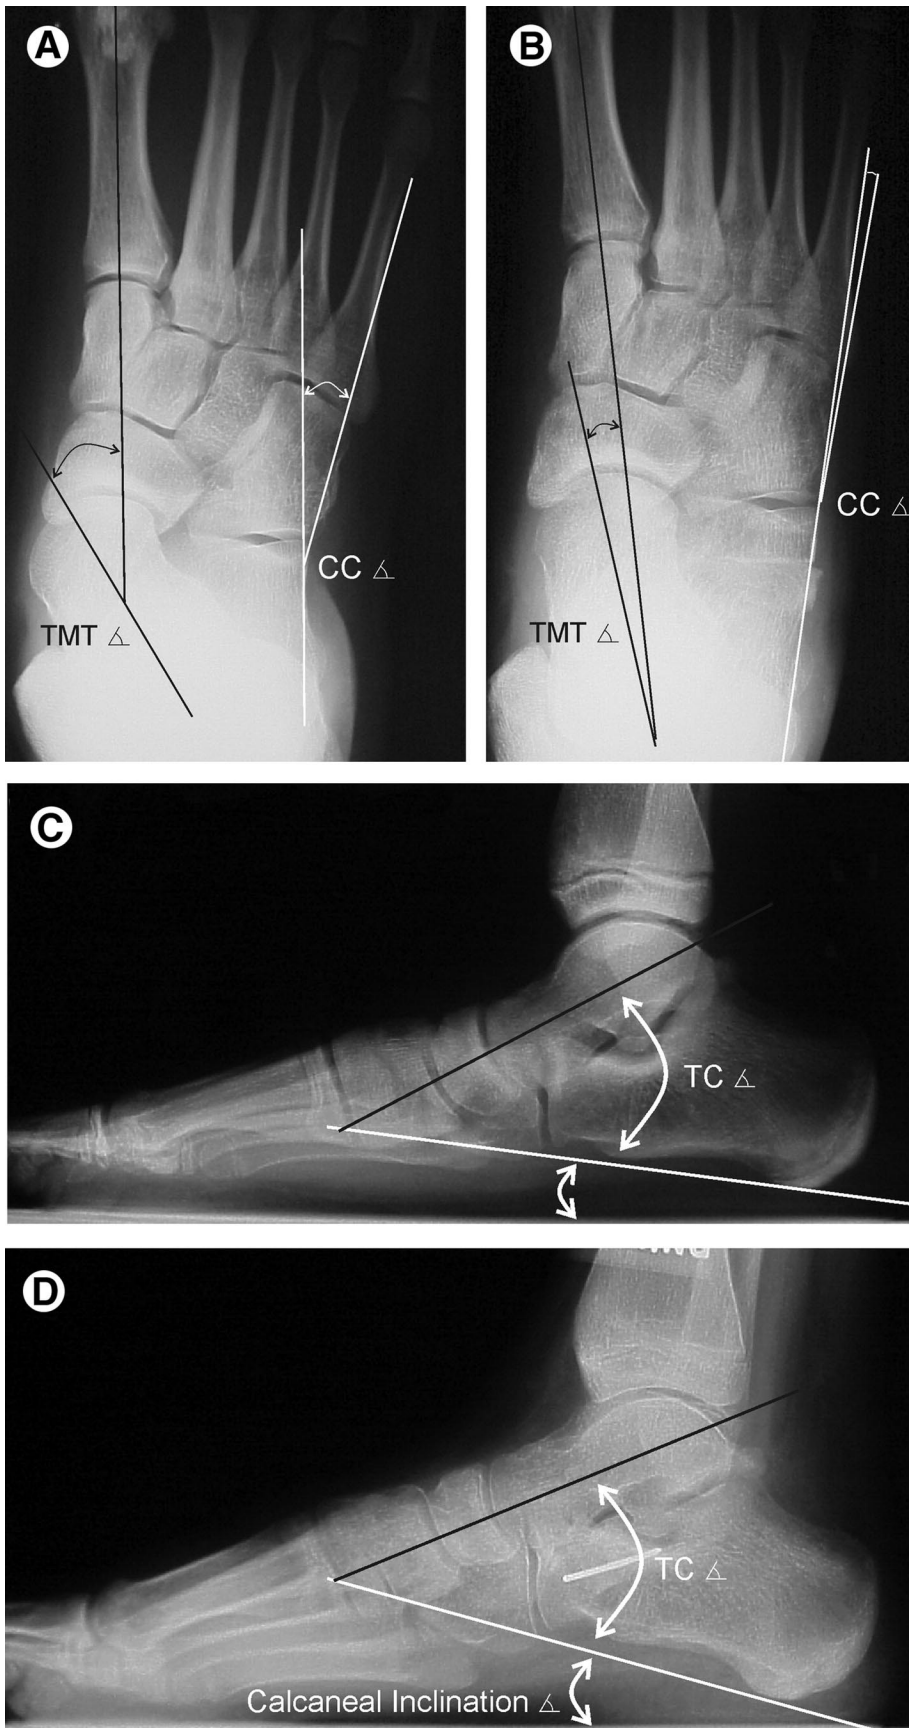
(A) This preoperative weight-bearing AP radiograph of flatfoot deformity shows increased calcaneocuboid (CC) and talo-first metatarsal (TMT) angles. An Evans calcaneal osteotomy with bone graft lengthening was performed, and (B) the postoperative weight-bearing AP radiograph shows reduction of fore-foot abduction and reduction of respective calcaneocuboid and talo-first metatarsal angles. Lateral (C) preoperative and (D) postoperative radiographs show similar improvement in biomechanical relationships.
